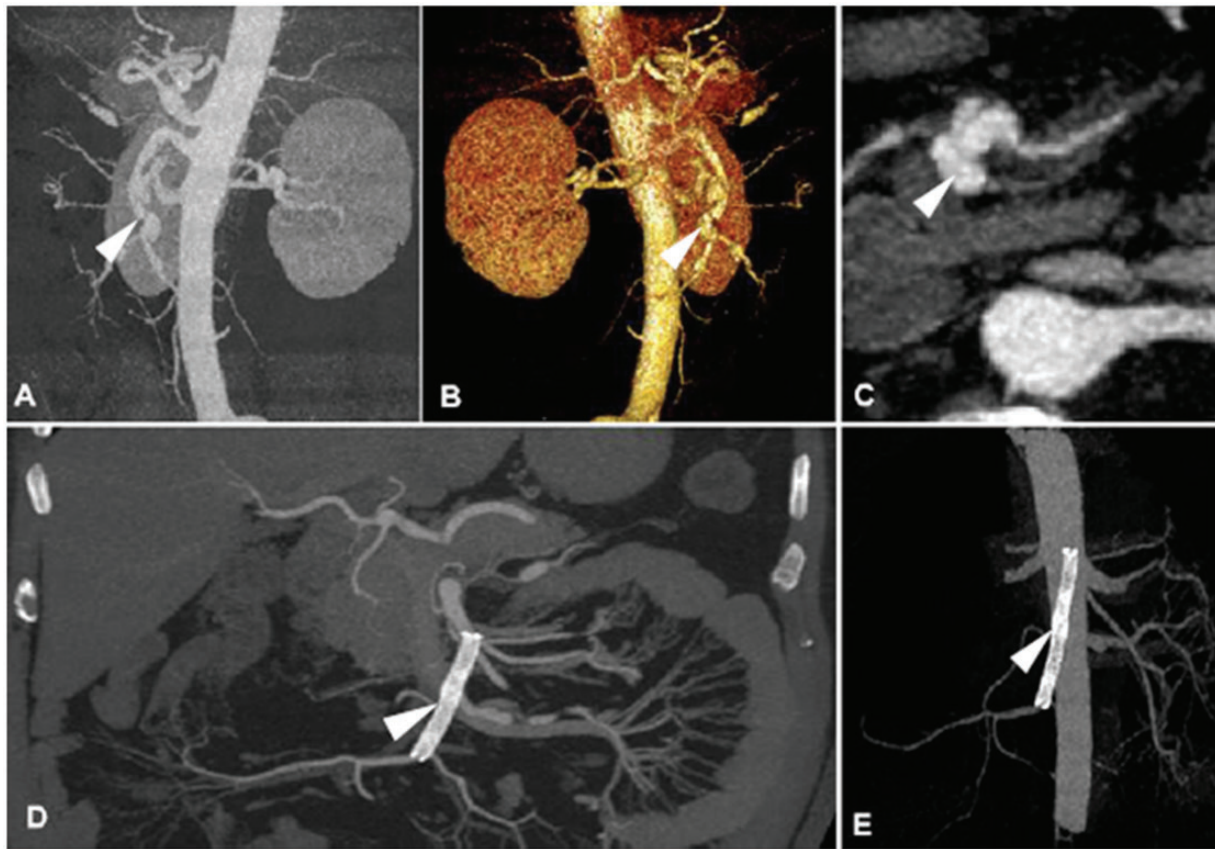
Symptomatic ISMDA was treated with conservative management for 24 months, and enhanced CT showed beaded changes in the SMA during follow-up (a to c, arrow). After the stent implantation for the dissecting aneurysm of the SMA, there was no obvious low-density filling defect in the lumen and the stent expanded well (d and e, arrow).
